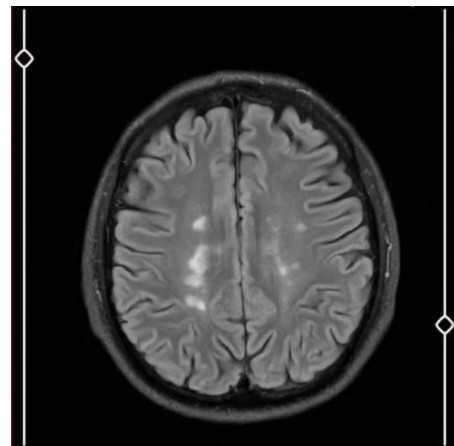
Patient Brain MRI Image. There are T2 hyperintense lesions in bilateral middle cerebellar peduncles and pons. Disseminated T2 hyperintense lesions were observed in both cerebral hemispheres, with periventricular localization, mostly affecting the frontoparietal lobes, but also affecting the temporal and occipital lobes.
